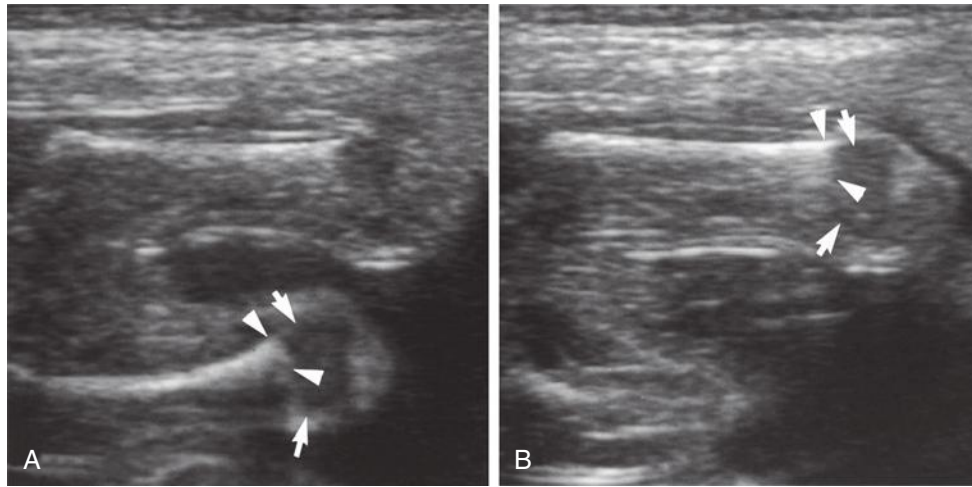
A, Sonogram best demonstrating the femur farther from the transducer. Arrows mark the edges of the distal epiphysis. Arrowheads mark the apparent “edges” of the distal femoral diaphysis. The more medial edge of the diaphysis matches the edge of the medial condyle, but the lateral edges of “diaphysis” and lateral condyle are widely disparate. B, The same exercise can be performed on the nearer femur. Again, arrows mark the edges of the distal epiphysis, and arrowheads mark the “edges” of the femoral diaphysis. Shadowing by the bone but not the cartilage causes this deceptive appearance.
